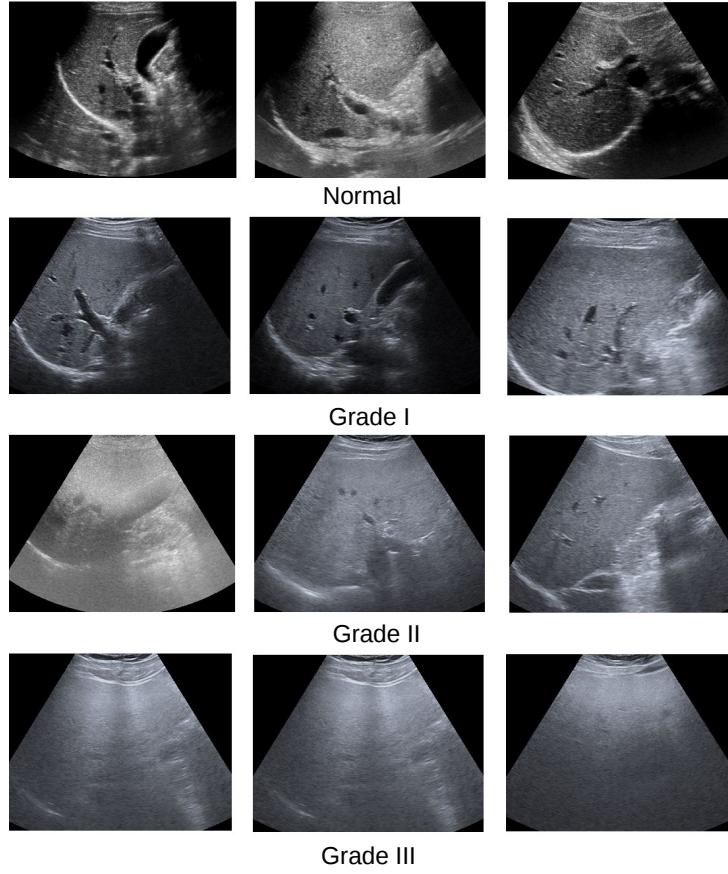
Ultrasound images correspond to different grades of nonalcoholic fatty liver. Images in each row belong to single category. We can observe minute differences in the characteristics of RoI across all grades of fatty liver images.
